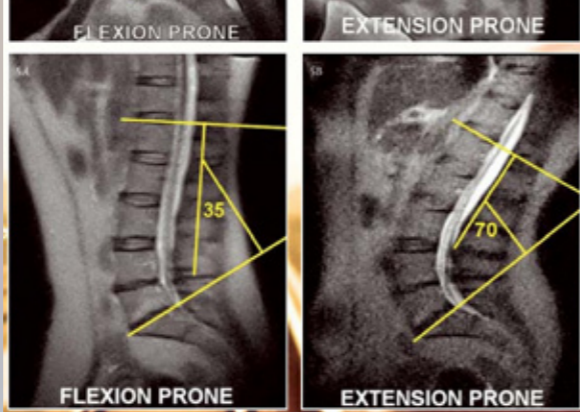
HASTE images showing COBB angles for an asymptomatic female volunteer undergoing (A) flexion and (B) extension lumbar spine MRI (range of motion 35°).
